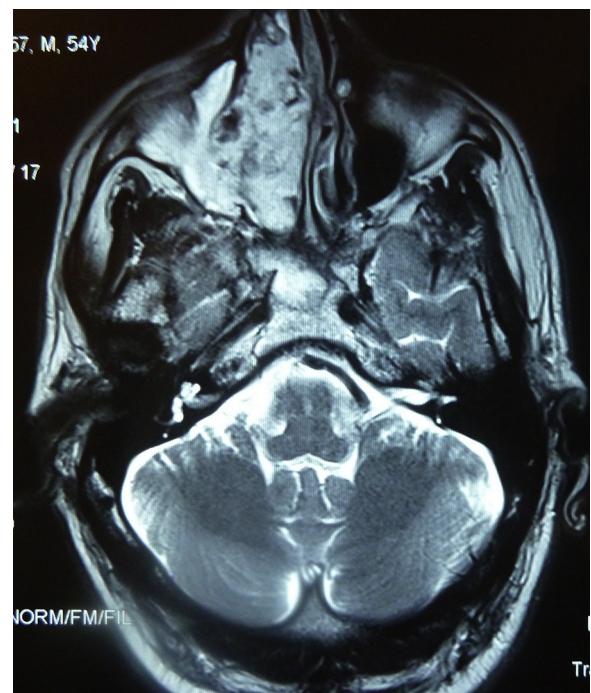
Naso-ethmoid recurrence with heterogeneous high-intensity signal on the T2-weighted sequence.
